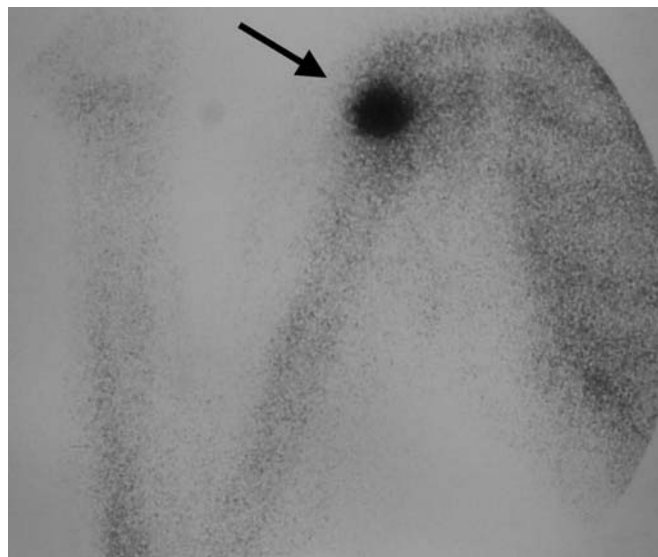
Methylene diphosphonate delayed phase bone scintigraphy of the right shoulder, showing abnormal uptake due to calcific tendonitis (arrow).
